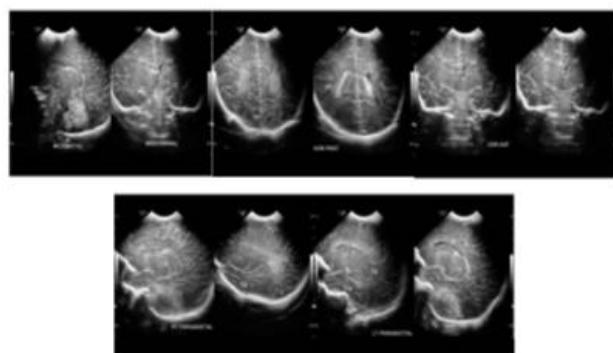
Head Ultrasound (RSMS November 13, 2024)
